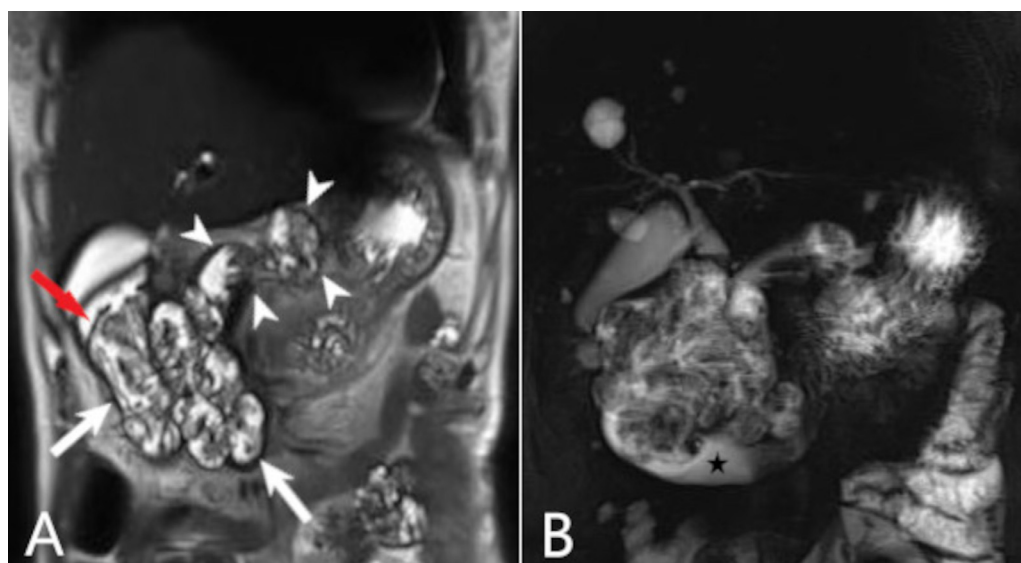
Coronal T2 magnetic resonance imaging and MRCP. (A,B) Multiple frond-like, hypointense papillary projections within a dilated main pancreatic duct (arrowheads) and duodenal second portion (white arrows) are observed. Some overlying duodenal mucosa was intact (red arrow). MRCP showed findings similar to those of T2 coronal MRI scans (star: lumen of the duodenum).
